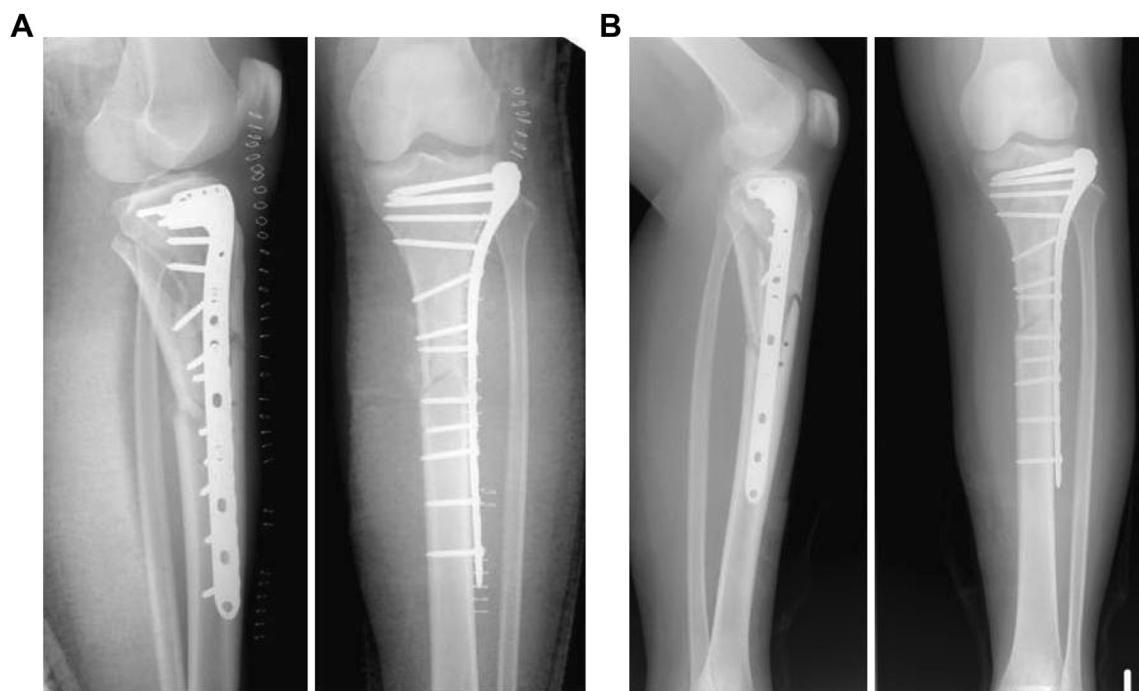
(A) Preoperative radiographic presentation of patient #8. (B) Postoperative anteroposterior and lateral X-rays of follow-up revealed loss of fixation with varus alignment.
